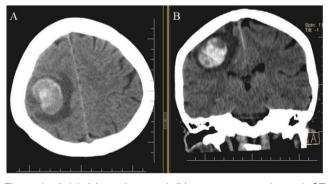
Axial (a), and coronal (b) non-contrast-enhanced CT shows a hematoma in the right frontoparietal lobe surrounded by hypodense edema.
